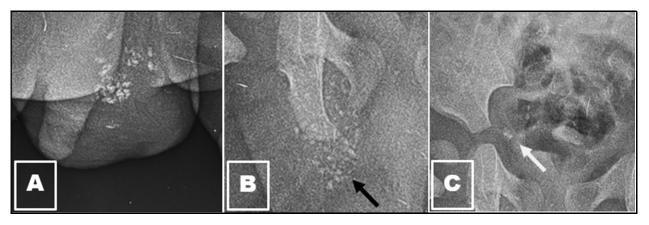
Plain radiograph of patient 1. Magnified close-up views showing calcifications (arrows) in the left scrotum (A), the right groin (B) and the peritoneal cavity (C).
